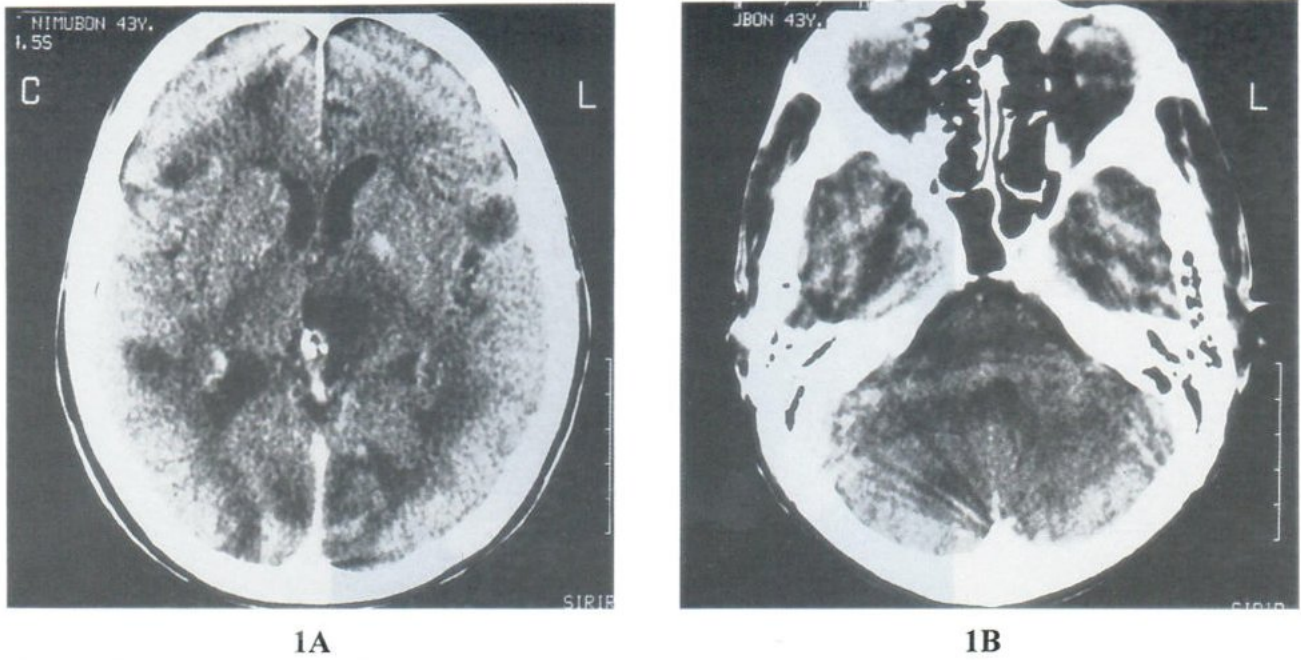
Contrast enhanced CT of Case 1 (A,B) demonstrate multiple low density areas in supratentorial and infratentorial location with some faint enhancement.
